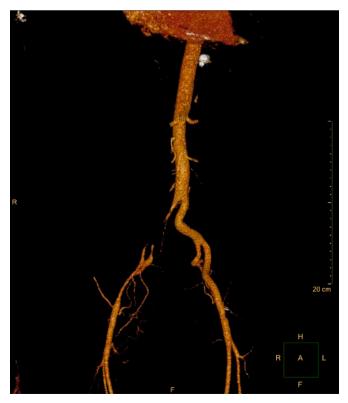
CT angiogram of the aorta revealing a chronically occluded right common iliac artery.
